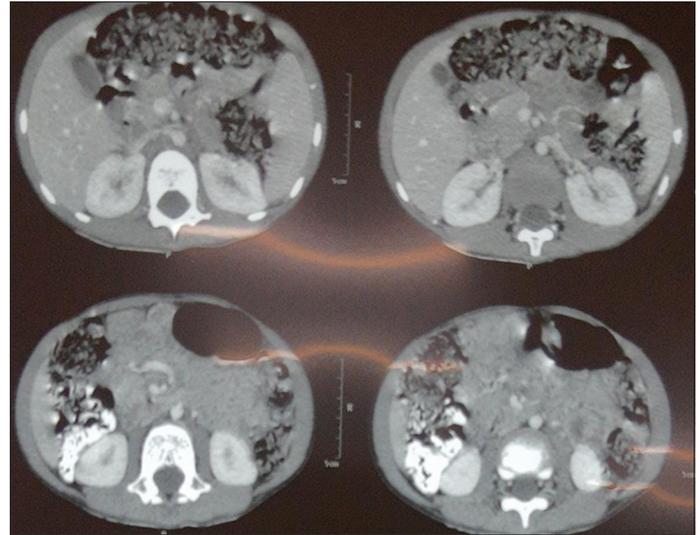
Contrast-enhanced computed tomography abdomen showing right renal vein thrombosis
